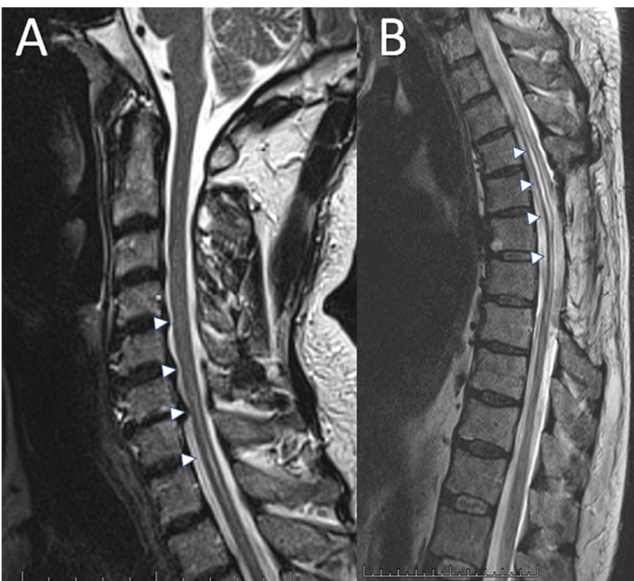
Preoperative T2 STIR MRI of the cervical (A) and thoracic spine (B) demonstrating a dilated syrinx within the spinal cord extending from the cervical spine to T6 (arrowheads). Note the arachnoid cyst displacing the cord ventrally (arrows).
